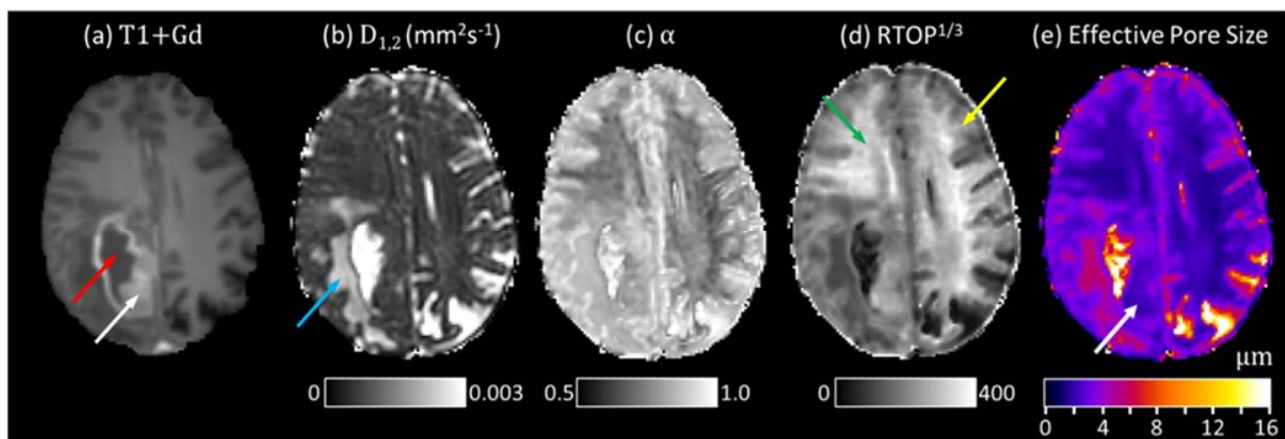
Quasi-diffusion imaging results for axial slices through a high-grade glioma (WHO Grade IV glioblastoma). Diffusion magnetic resonance imaging data were acquired at $b = \{0, 1100, 5000\} \text{ s mm}^{-2}$ in 6 diffusion encoding directions at an effective diffusion time of $\bar{\Delta} = 35.9 \text{ ms}$. Imaging data were acquired in a clinically feasible time of 120 s. Image (a) shows a T1-weighted image acquired after injection of gadolinium contrast agent, with maps of (b) mean $D_{1,2}$, (c) mean α , (d) $\sqrt[3]{RTOP}$ and (e) effective mean pore size, $\langle R \rangle$, (which in the absence of oedema or necrosis will relate to cell size). Arrows indicate the following regions: white—tumour core, red—necrosis, blue—oedema, yellow—grey matter, green—white matter.
